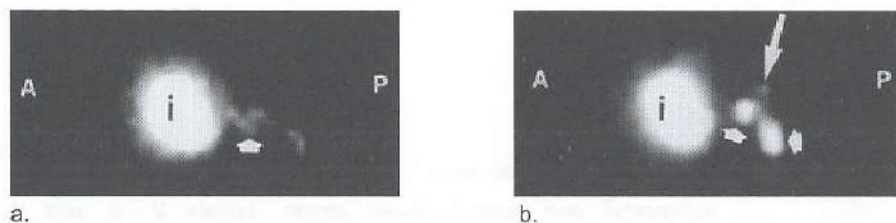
Patient 11. (a) Left lateral dynamic lymphoscintigram obtained at 2 minutes after peritumoral injection of ^{99m}Tc -labeled colloidal albumin shows early transport of the tracer in a lymph vessel (arrow), without focal activity. (b) Left lateral static scintigram obtained at 20 minutes after injection shows two radiolabeled lymph nodes (short arrows) and a faint secondary focus (long arrow) above both lymph nodes, which represents spill of the radioactive tracer to a second-echelon lymph node. Fine-needle aspiration and cytologic findings of both radiolabeled lymph nodes were negative. In a and b, A = anterior, i = injection site, P = posterior.
